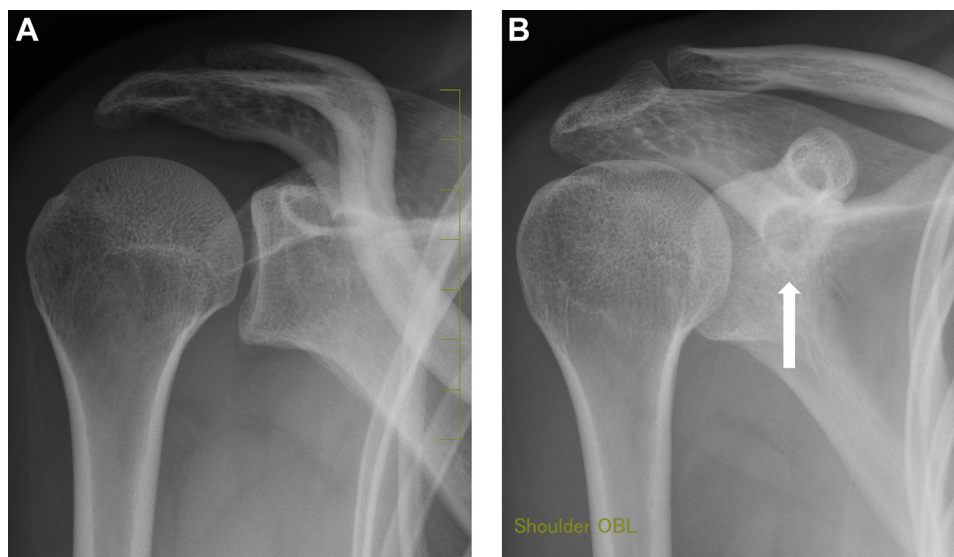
(A) True anteroposterior radiography: the tumor is indistinct. (B) An anteroposterior view of the nidus below the coracoid process (arrow).
